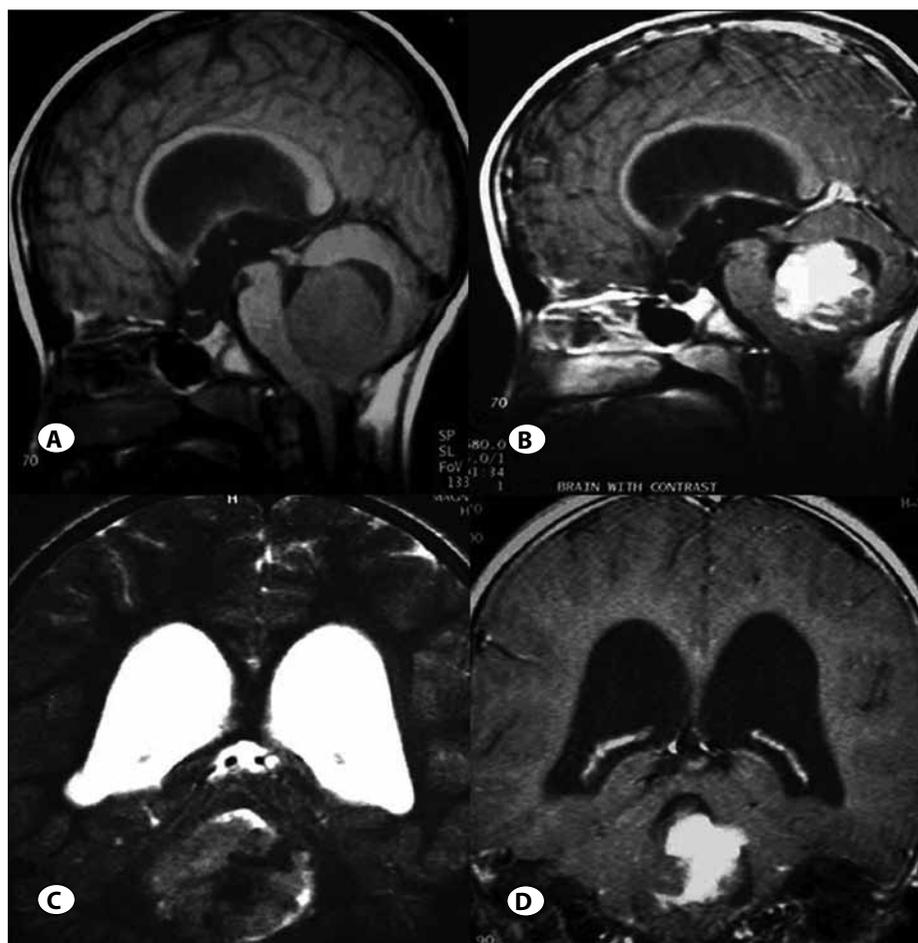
Preoperative MRI images of a patient with fourth ventricular medulloblastoma (Case 3). The tumor is seen obstructing the fourth ventricle with supratentorial hydrocephalus. (A) Sagittal T₁-weighted without contrast; (B) Sagittal T₁-weighted with contrast; (C) Coronal T₂-weighted; (D) Coronal T₁-weighted with contrast images.
